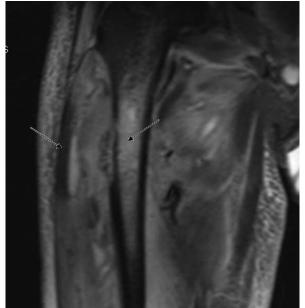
Magnetic resonance imaging cross section of the right femur showing osteomyelitis with intra- and extraosseous involvement and surrounding soft tissue abscess.
